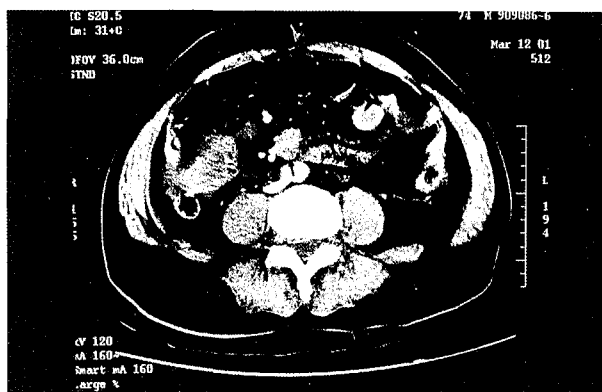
Post-contrast CT of the abdomen shows a mass lesion, 2 x 3 cm in size, in the small bowel (arrow), with dilatation of the bowel lumen.
